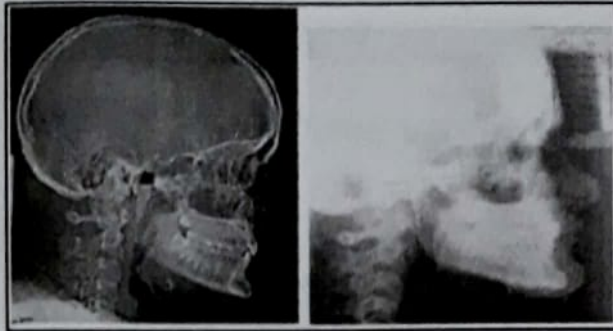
Measurement of ramal length in CT and lateral ceph.
